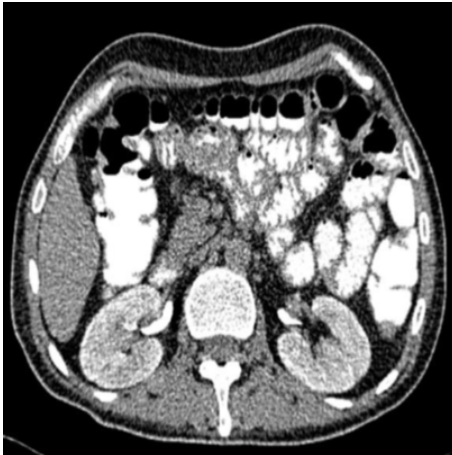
Intestinal wall thickening in the axial slice of abdominopelvic CT
